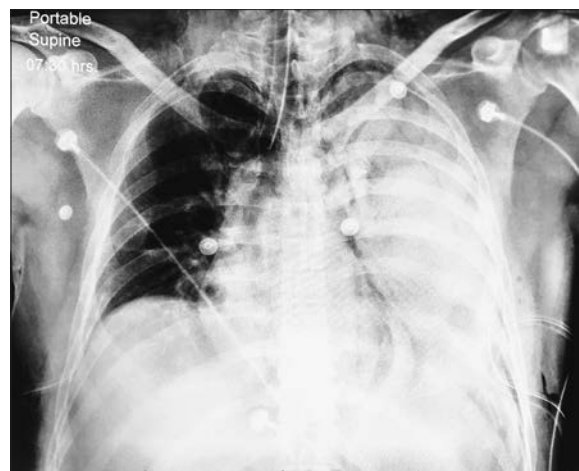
Chest radiography showing near-complete opacification of the left hemithorax. Endotracheal tube in place with tip 2.9 cm superior to carina. Bilateral chest tubes in place.
